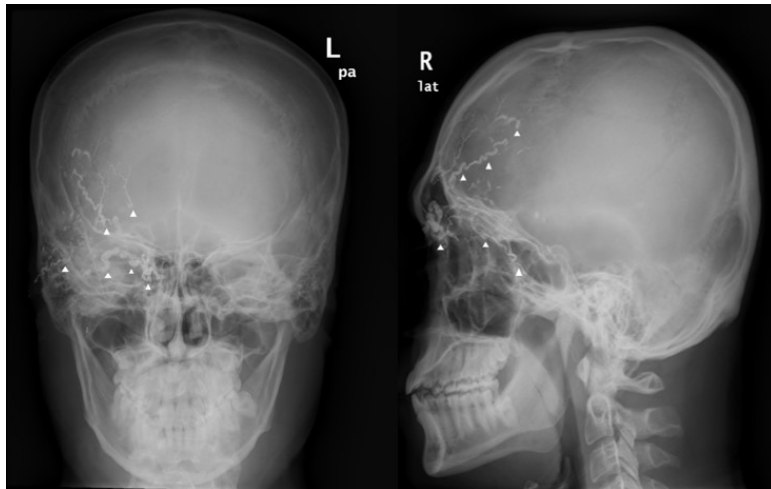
AP and lateral plain head X-rays: Linear, continuous, tortuous opacities (arrowheads) extending from the right periorbital region to the right frontal and temporal areas, consistent with prior interventional embolization.
